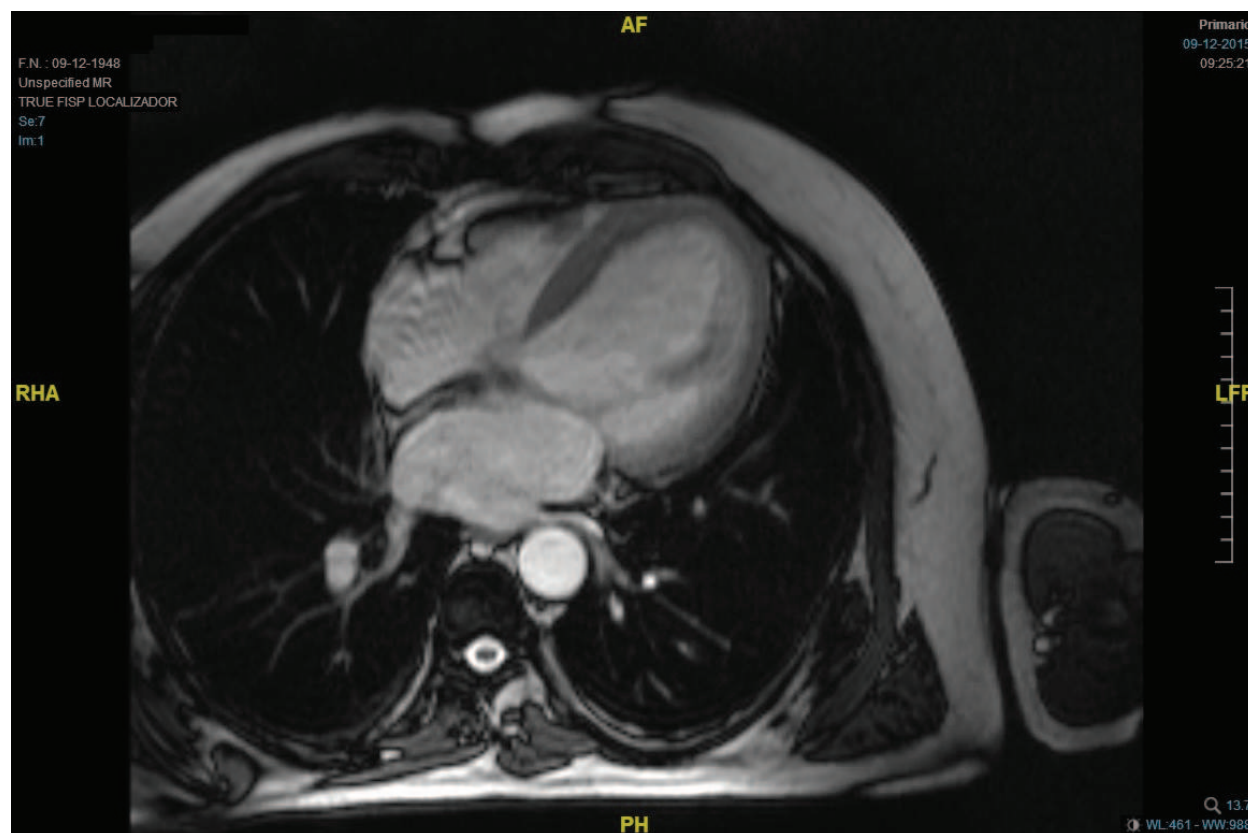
MR image of a patient with idiopathic dilated cardiomyopathy, with increased ventricular dimensions with a homogeneous myocardial uptake signal.
